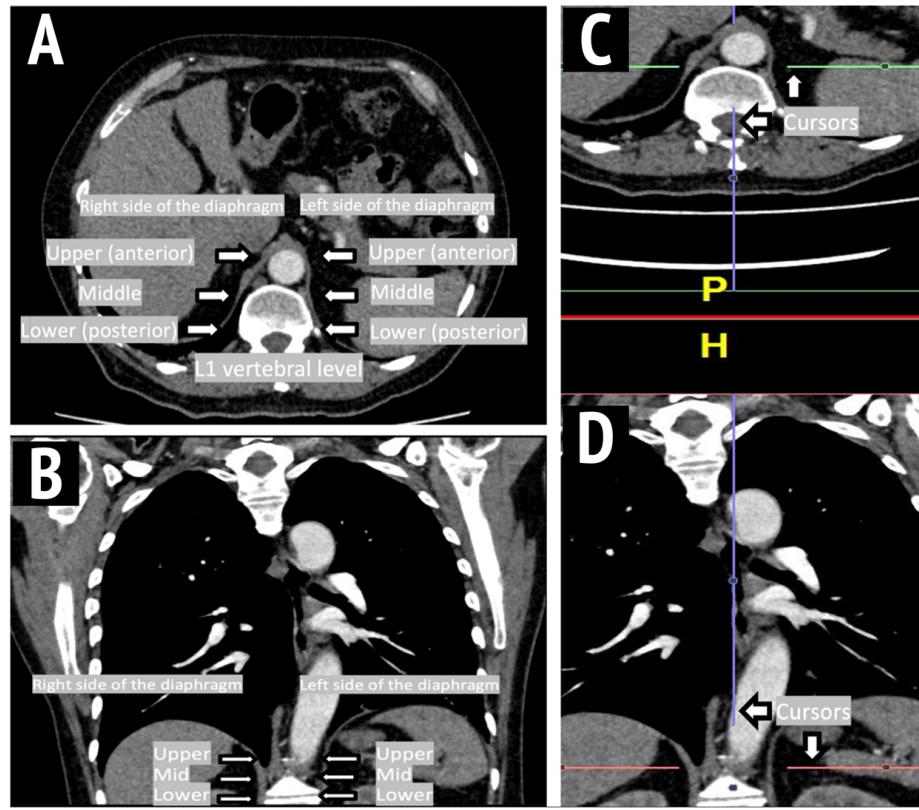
Location of the diaphragm muscle on cross-sectional imaging and the measurement of diaphragm thickness on chest CT scan. Panels A and B demonstrate location of the diaphragm measurements on axial (A) and coronal (B) planes, at the L₁ vertebral body level. The images show upper (anterior), middle, and lower (posterior) aspects of the diaphragm. Panel C and D shows multiplanar reconstruction demonstrating intersection points of the line and diaphragm on the coronal image when cursors were placed on the points of measurements in the axial image.
